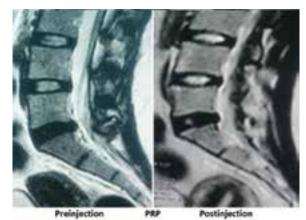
Pre-injection and post-PRP injection MRI showing improved disc hydration and mild diminution of the disc bulge
